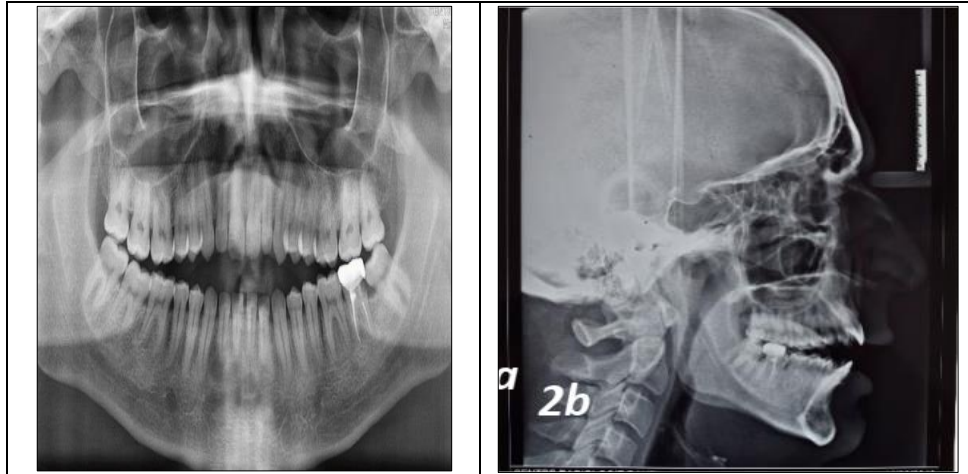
(a-b): Pre-treatment radiographs
